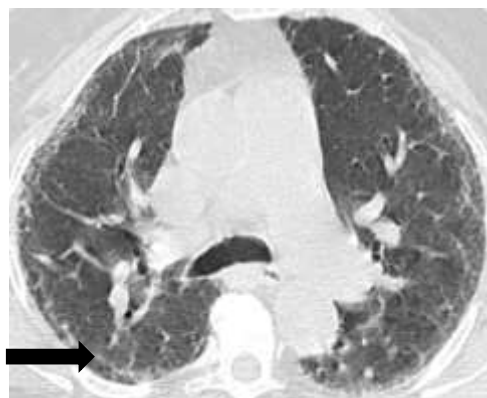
Axial HRCT image of the chest showing subpleural sparing sign (arrow).
